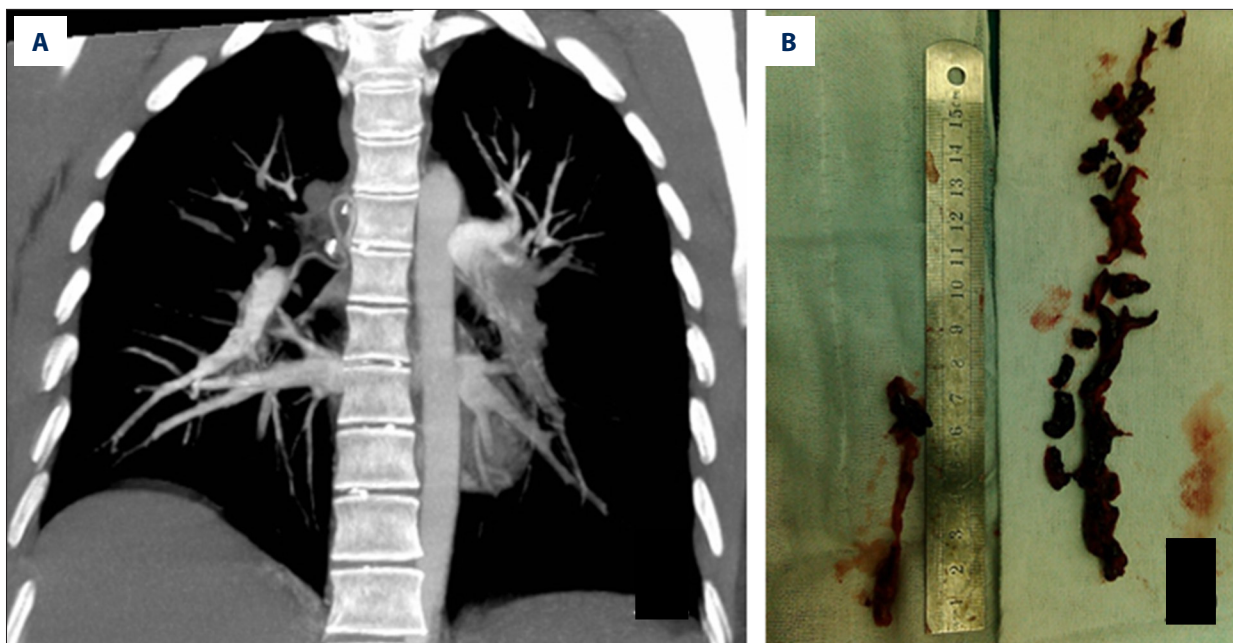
Pre- and postoperative images relating to case 4, who suffered sudden cardiac arrest. (A) Computed tomography angiogram showing the left pulmonary artery trunk to be completely blocked by the embolism. (B) Photograph of the surgically removed embolism.
